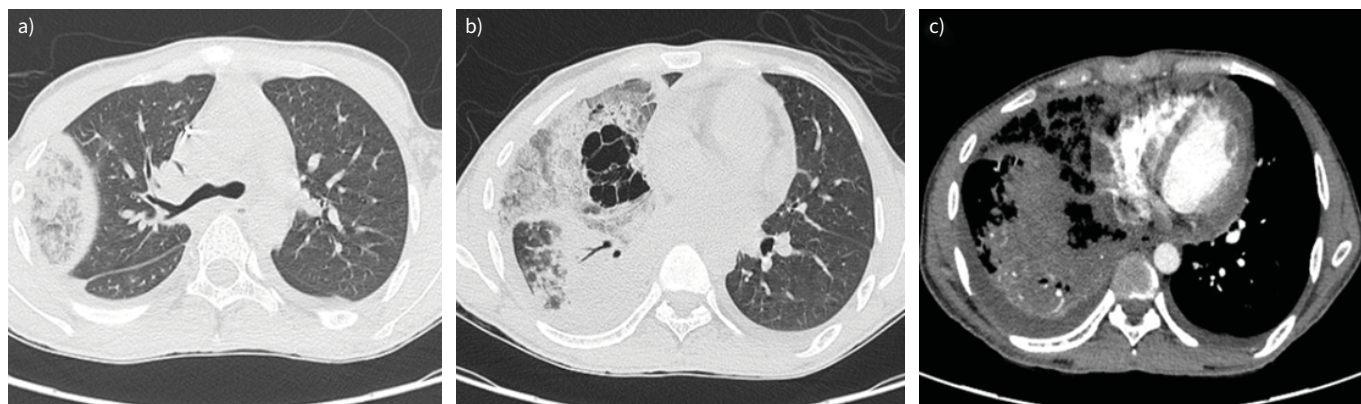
Computed tomography of the chest: a) lung window at the level of carina; b) lung window at the level of pulmonary veins entering the left atrium; and c) mediastinal window.
